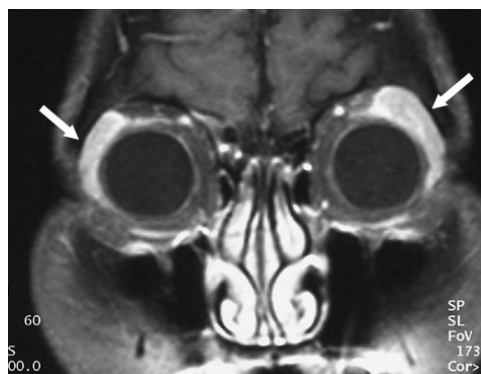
Chronic dacryoadenitis in a 39-year-old woman. A gadolinium-enhanced T1-weighted coronal image shows diffuse and elongated enlargement of both lacrimal glands with contrast enhancement (arrows).
